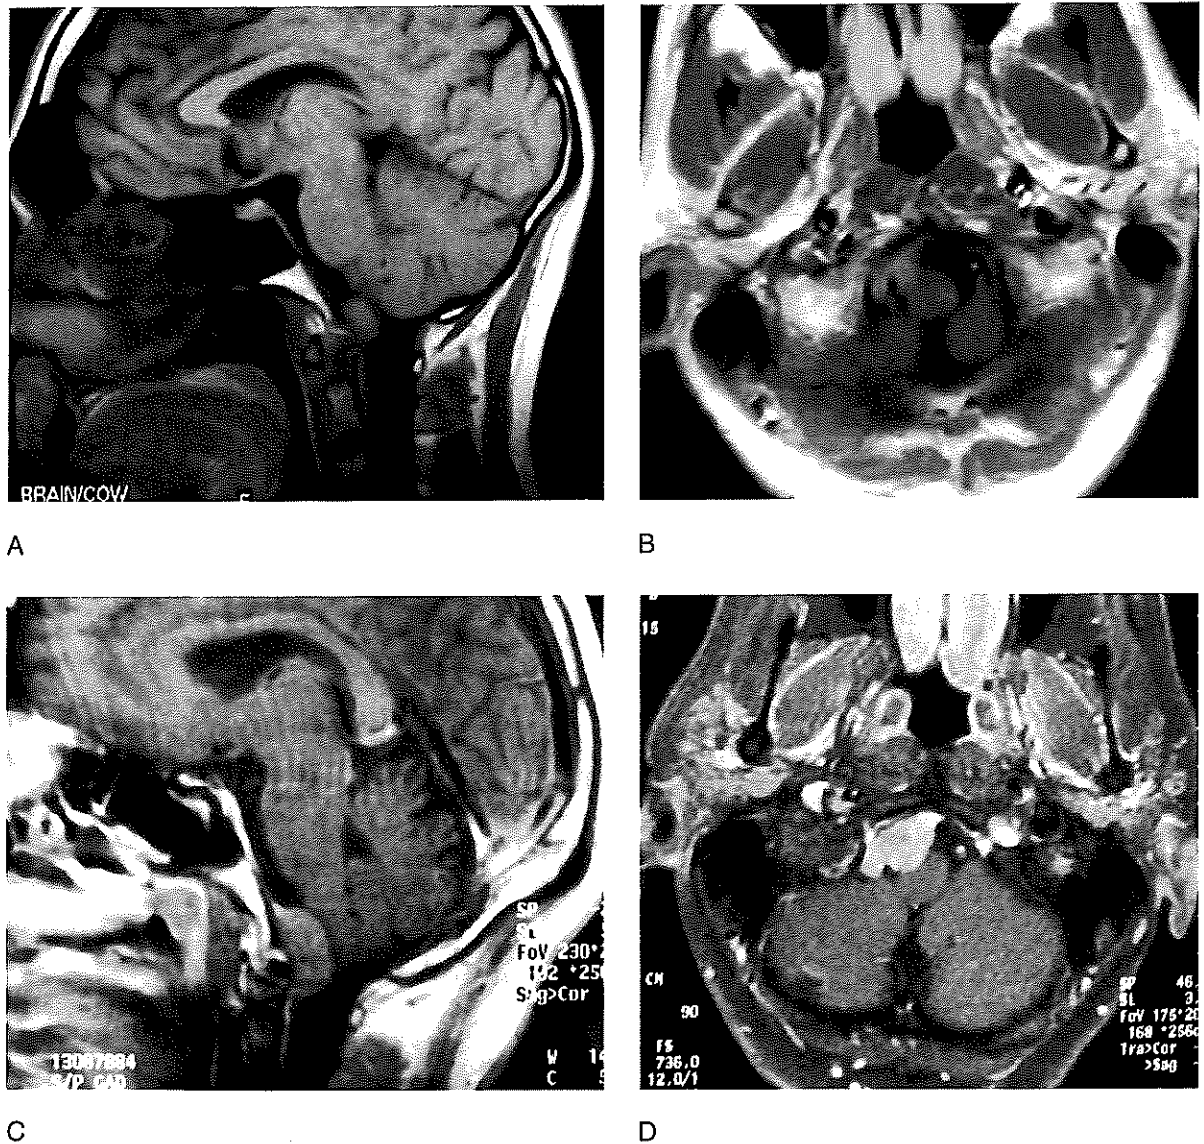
T1-weighted (A) sagittal and (B) postcontrast axial image of a 20-mm antero-lateral foramen magnum meningioma on the right. (C) Postcontrast sagittal and (D) axial views of the same patient with the tumor reaching 28 mm in size
